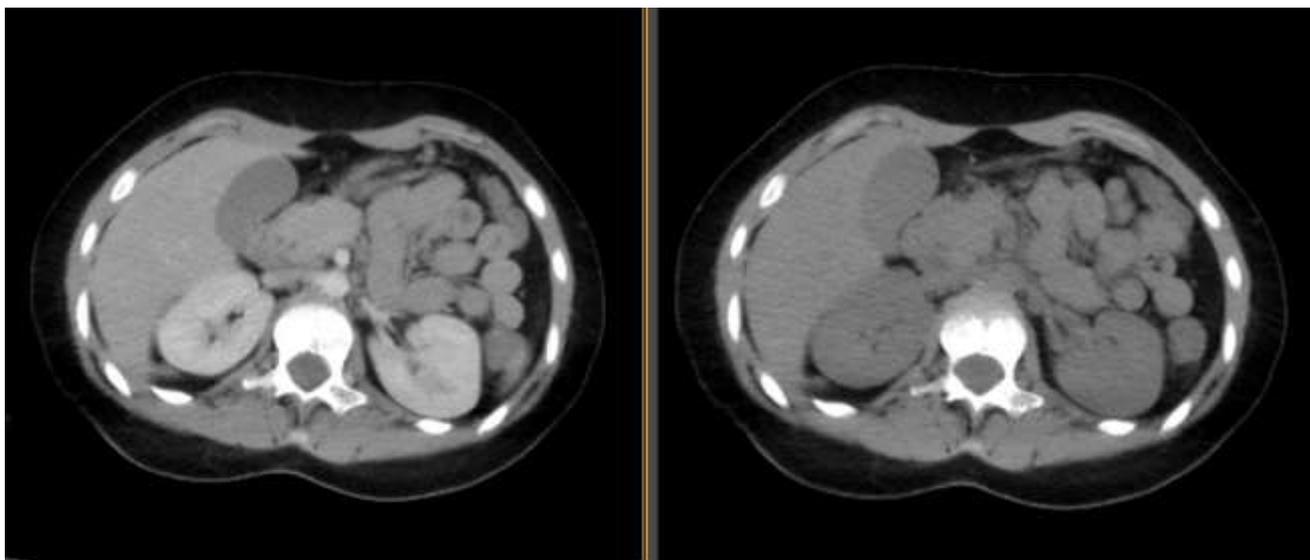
CT scan showed grade C of acute pancreatitis
